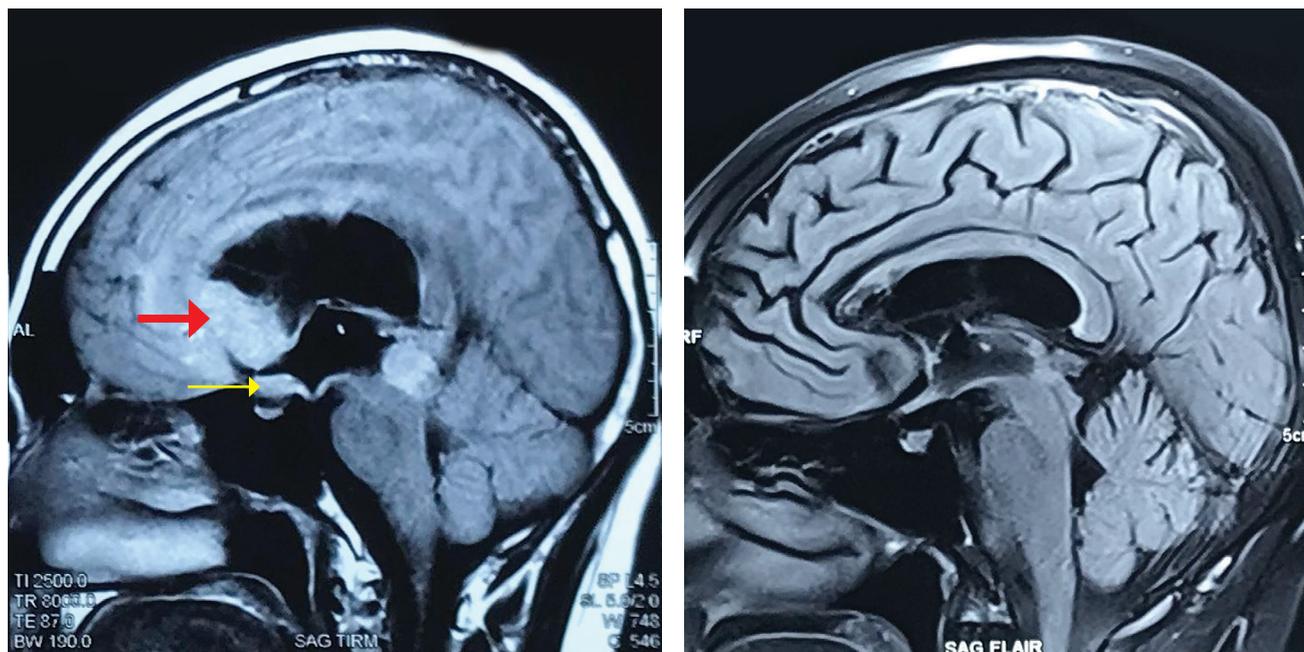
(A) Pretreatment cranial MRI in sagittal section. There was a 4.5 x 2.4 x 2.2 cm mixed signal predominantly isointense lobulated mass in the left frontal lobe parasagittal region extending across the midline with involvement of the anterior corpus callosum to the right frontal lobe (*thick arrow*). The mass encroached into the left frontal horn and anterior third ventricle. Mixed signal lesions were also seen in the pineal gland about 3.3 x 2.4 x 2.2 cm and in the suprasellar region measuring about 1.7 x 0.9 cm (*thin arrow*). There was also moderate non-communicating hydrocephalus. (B) Posttreatment cranial MRI in sagittal section showing tumor size reduction (1.6 x 0.8 cm) in the frontal lobe and resolution of suprasellar and pineal masses.
